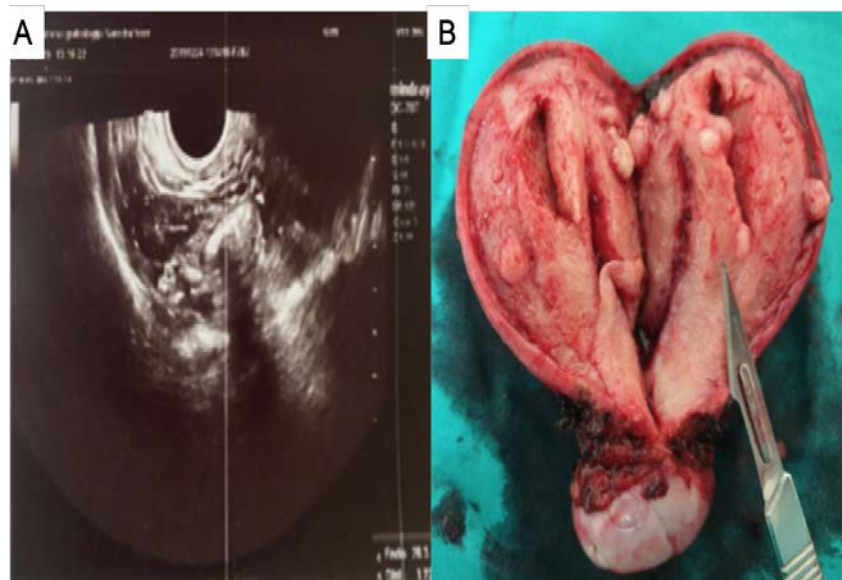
A) Ultrasonographic image in the second patient before the operation: the suspect development of a gestational trophoblastic neoplasm (GTN) in the uterine corpus; B) Uterus after the hysterectomy.
